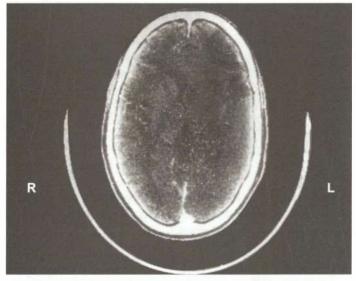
Cranial CT: Hypodensity of the left (L) frontoparietal cerebral parenchyma suggestive of a (L) middle cerebral artery territory infarct
